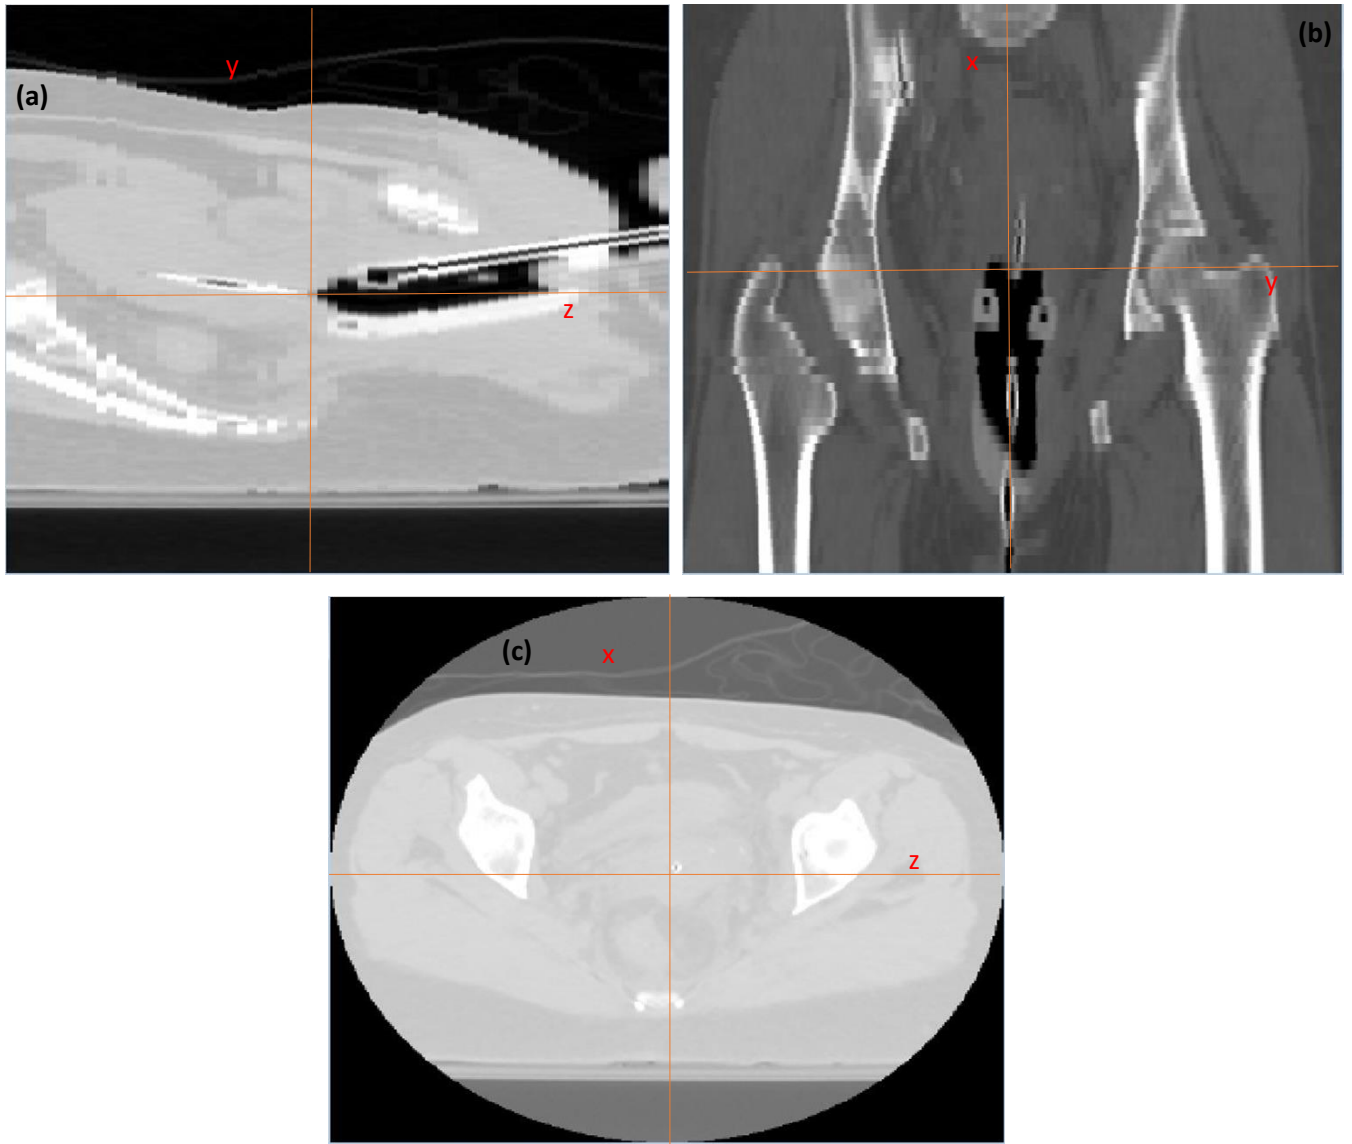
Visualisation of CT data with applicator in situ, in three anatomical planes by the IHDM. (a) Sagittal view, (b) Coronal view and (c) Axial view.
